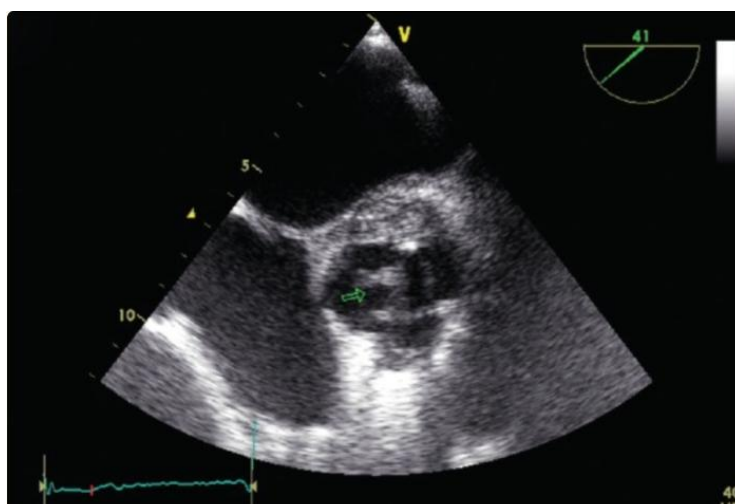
Transesophageal echocardiography showing a small echogenic vegetation (length 5 mm, thickness 3 mm) on the cusp of the bioprosthetic aortic valve associated with a posterior abscess [17]
